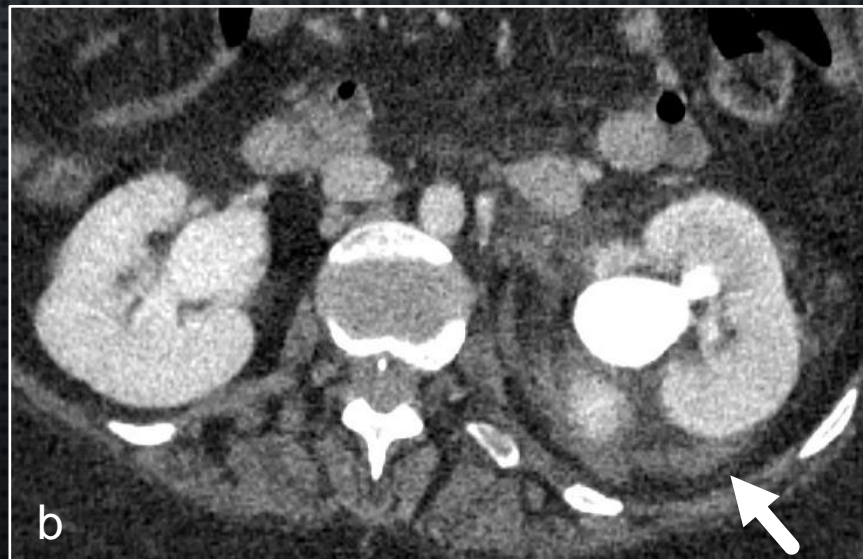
Contrast-enhanced CT in 41-year-old female with multiple sclerosis and neurogenic bladder presenting with left flank pain 7 days post suprapubic bladder catheterization. Axial image (a) shows suprapubic catheter tip extending into left ureteral orifice (black arrow). Axial image (b) shows left hydronephrosis, delayed nephrogram, and perinephric fat stranding (white arrow).
